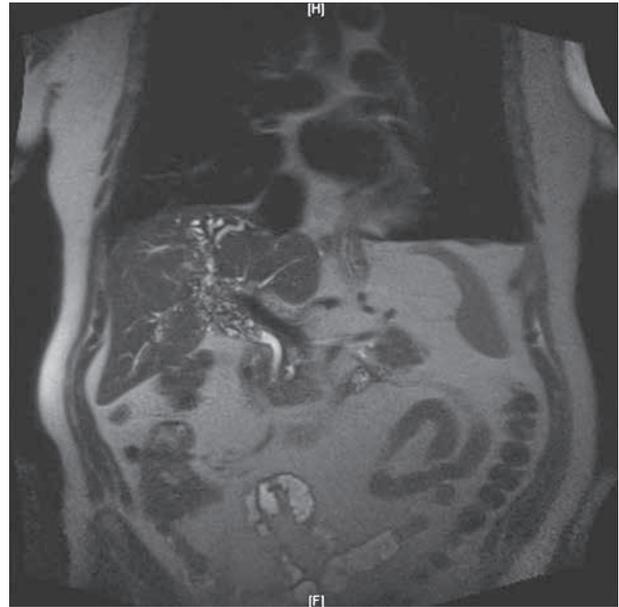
Coronal plane T2-weighted magnetic resonance showing numerous clustered small cysts (metacestodal vesicles) invading the liver hilum and hepatic pedicle.
